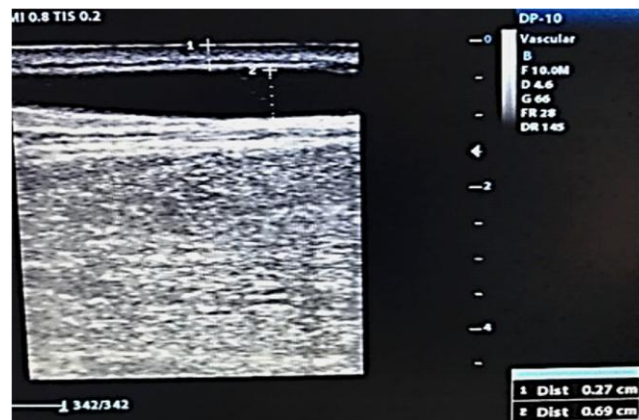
Ultrasound image of a native arteriovenous fistula with a distance from the skin of 0.27 cm and a vein diameter of 0.60 cm. Source. Document obtained during the conduct of the study.
